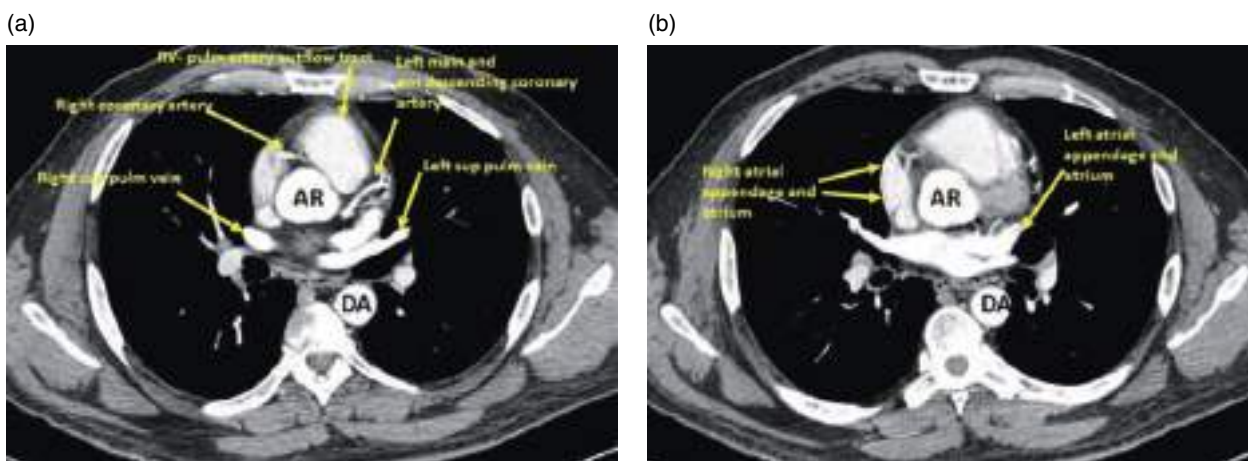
Paracardiac mediastinum. (a, b) Axial contrast-enhanced CT images (mediastinal window). AR, aortic root; DA, descending aorta.
